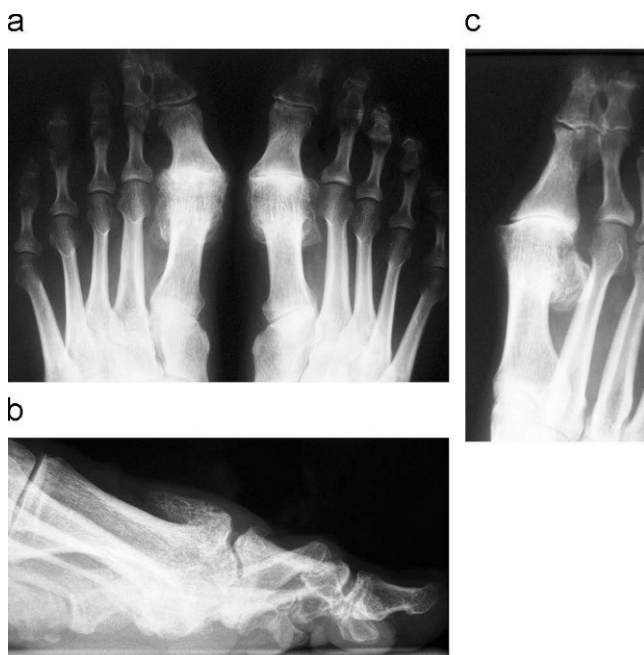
X-ray of hallux rigidus. a) Standing, posteroanterior radiograph of the feet, with complete loss of joint space of the first metatarsal-phalanges of both feet. b) Standing, lateral radiograph showing the dorsal, tear-shaped osteophyte characteristic of hallux rigidus. c) Oblique radiograph showing the actual joint space, by absence of interposition of osteophytes.
